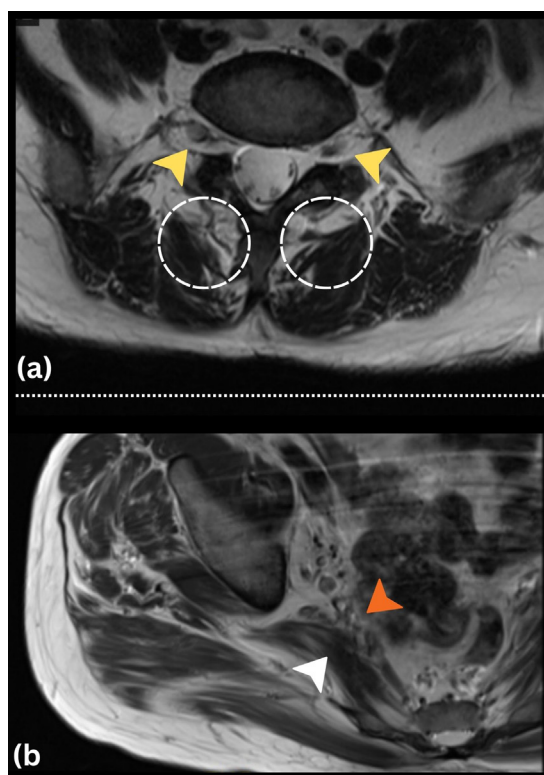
(a) show an MRI image axial T2 weighted image of L4-L5 region. Note that there is preserved foraminal space (yellow arrow head) with no impingement at L4 and L5 nerve root. Noted mild atrophy over bilateral multifidus (white circle). Figure 1(b) showed MRI image of left hip in axial view, showing normal bulk piriformis (white arrow head) with no impingement over neurovascular bundle (orange arrowhead).
